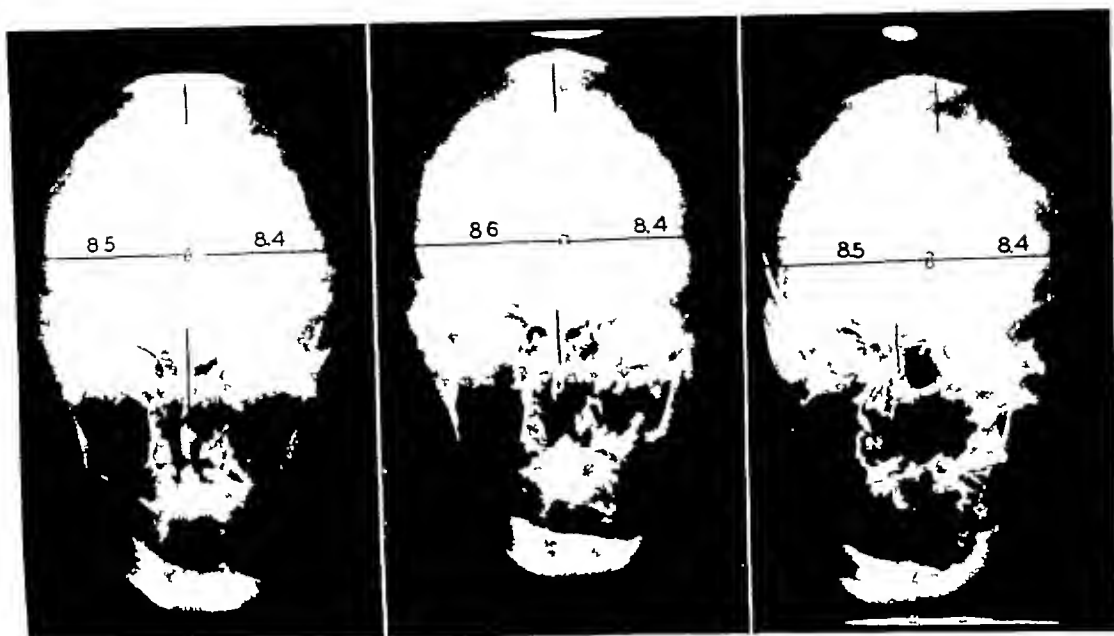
Anteroposterior films of normal adult male, showing effect of rotation of the head. The pineal was densely calcified and could be readily identified regardless of the degree of rotation. The radiograph at the left shows the skull without rotation, the middle one with a slight degree of rotation, and the one on the right with marked rotation. The distances from the pineal to either side of the skull do not vary more than 2 mm (normal variation), regardless of the degree of rotation.
